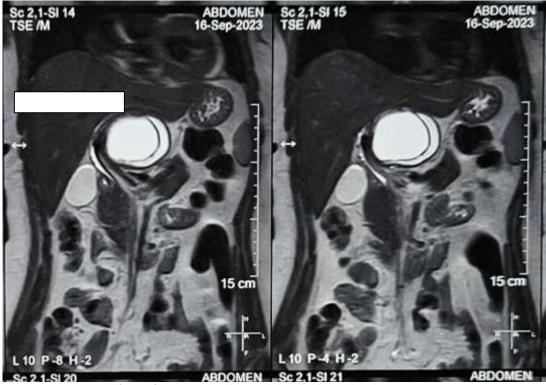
MRI Showing peripheral thin wall enhancement.
